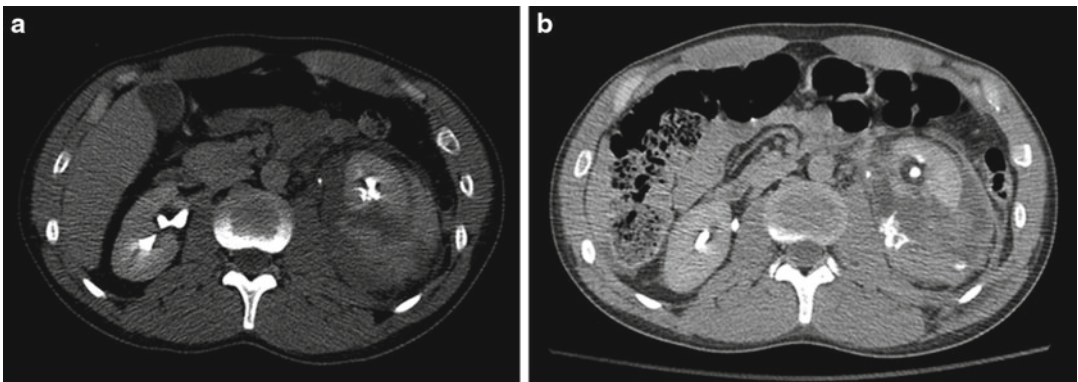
A 45-year-old male status post-auto vs. scooter injury. Initial CT scan with delayed images at the time of admission revealed no obvious urine leak, but there was a heightened suspicion for injury (a). Repeat imaging 48 h
